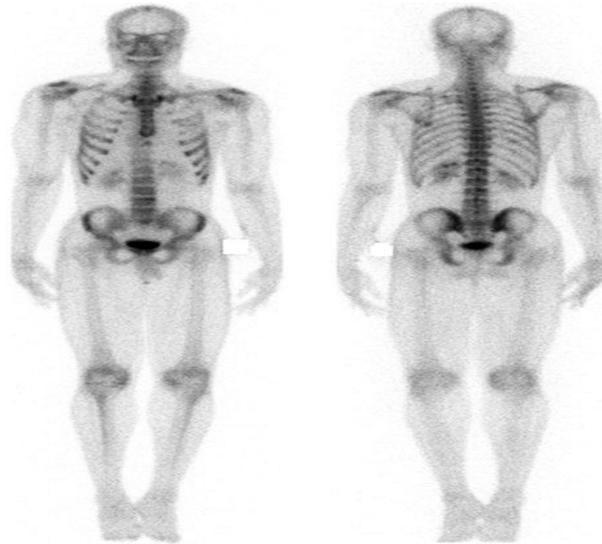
Skeletal scintigraphy
